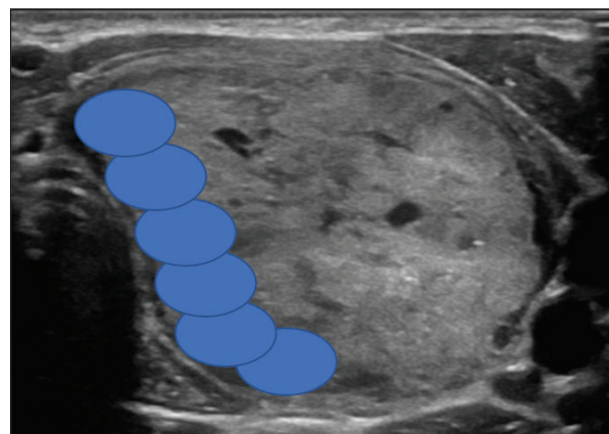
B-mode ultrasound image demonstrates a left-sided thyroid nodule. Overlapping circles demonstrate the ablated subunits after an initial first pass during ablation.
